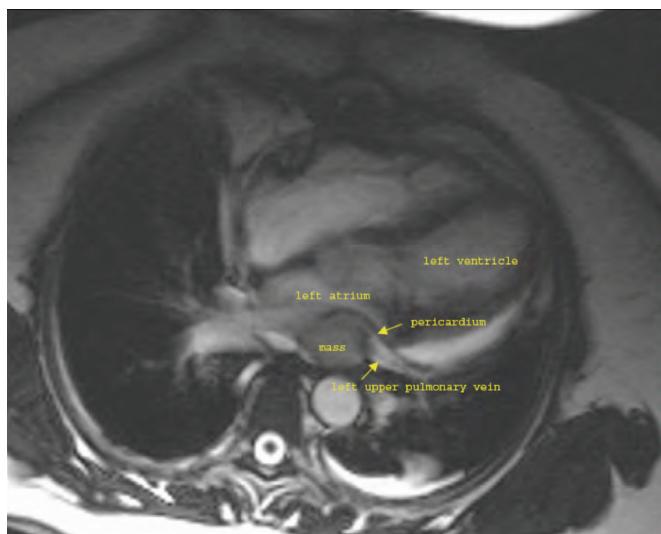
Axial magnetic resonance imaging (MRI) shows the residual tumor invading the pericardium and extending into the left atrial cavity and left upper pulmonary vein.
